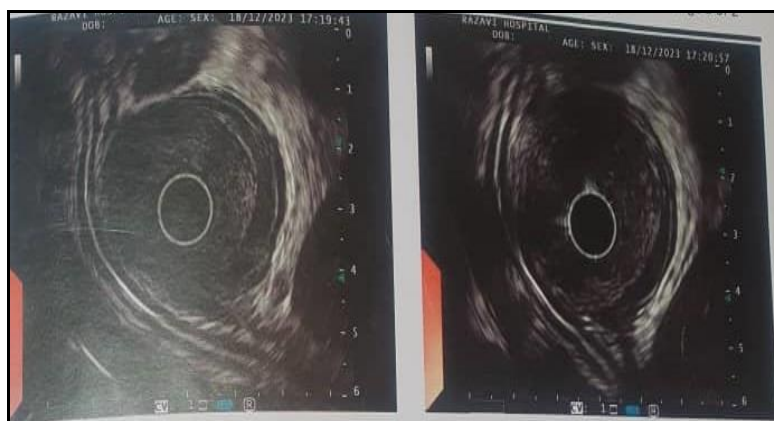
Endoscopic ultrasound (EUS) demonstrating a hypoechoic intramural/submucosal mass involving the distal thoracic esophagus with marked esophageal wall thickening; the imaging appearance favored a gastrointestinal stromal tumor (GIST) or leiomyoma as the principal differential diagnoses.
